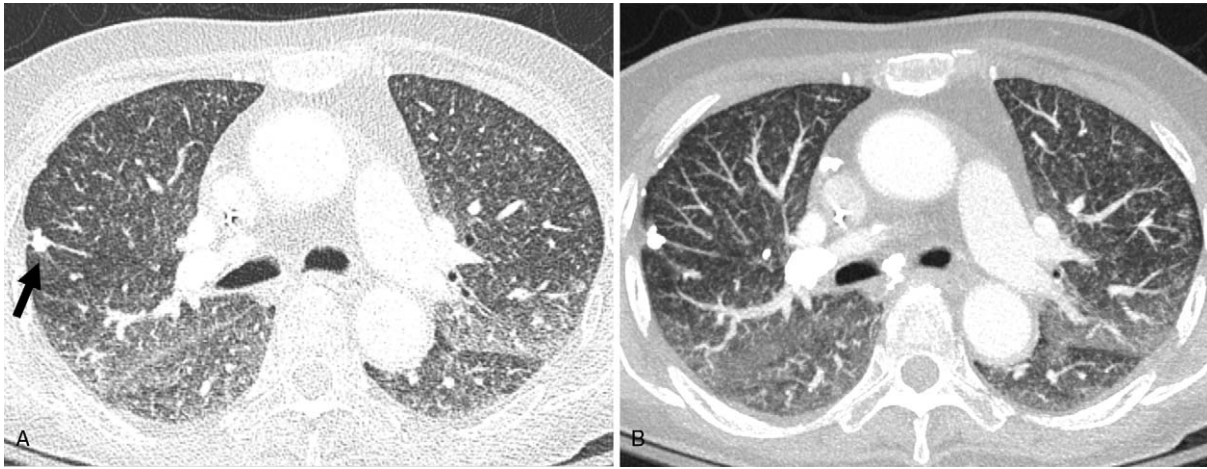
73-year-old woman with missed miliary TB. (a) Miliary TB in a 73-year-old woman admitted to hospital with persistent fever and underlying diffuse large B-cell lymphoma with ongoing chemotherapy. A lung window of an axial CT (1.0 mm section thickness) shows fine, ill-defined nodules predominantly < 2 mm in size and showing a coarse, granular appearance distributed throughout both lungs, with ill-defined, patchy ground glass opacities. A calcified granuloma is shown in right upper lobe, possible a sequelae of previous tuberculosis (arrow). Miliary TB was missed on the initial CT reading at symptom onset. The CT was interpreted as an atypical pathogen pneumonia, such as viral pneumonia or a drug reaction. (b) 8-mm axial maximum intensity projection (MIP) slab shows non-classic miliary nodules superimposed on same level of image, which is more conspicuous on MIP slab.
